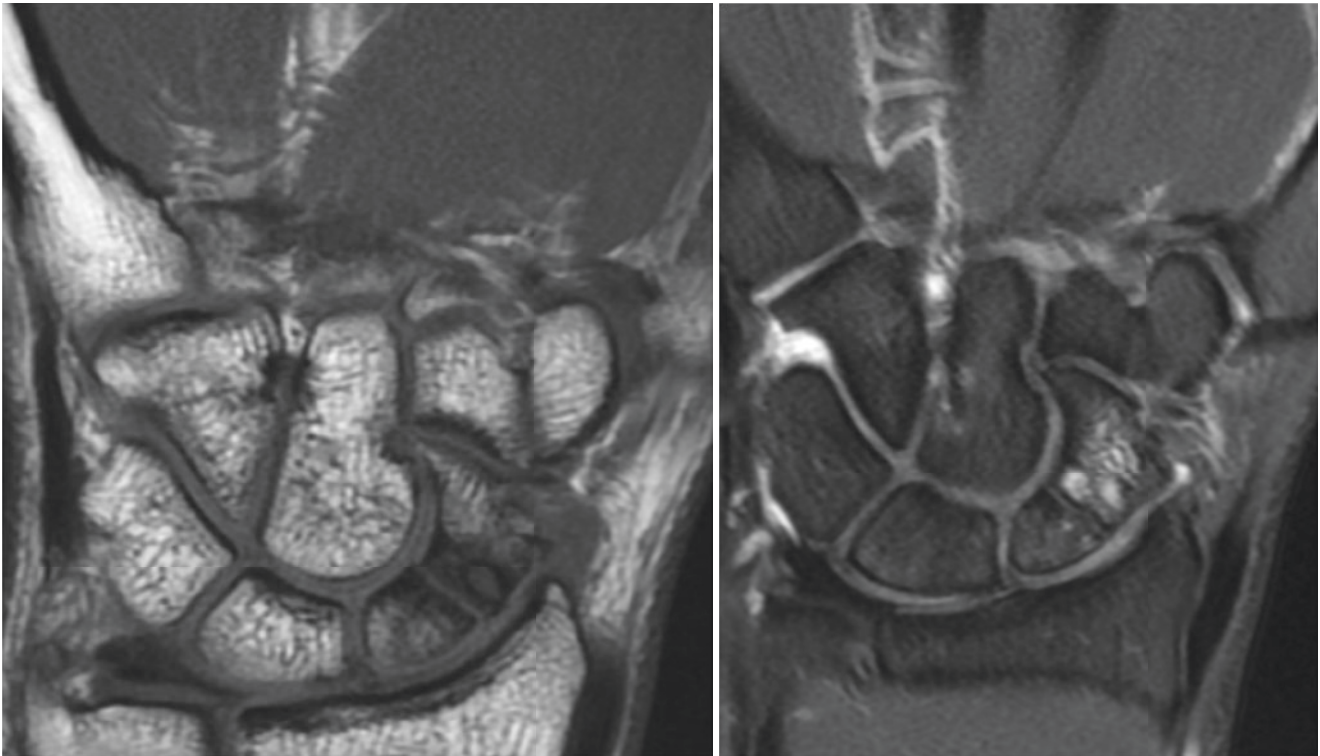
Scaphoid fractures could be occult on radiographs. Coronal MR images through the wrist demonstrate a chronic appearing minimally displaced fracture of scaphoid wrist
